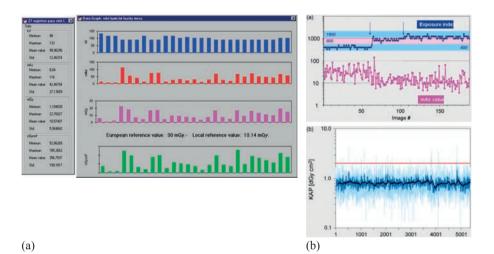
(a) An on-line patient dose monitoring system developed for computed radiography auditing [13]. (b) Top: anteroposterior lumbar spine radiograph exposure. Small alterations of the automated exposure control are indicated (arrows). Bottom: automated assessment of the kerma area product in posteroanterior chest radiographs. The majority of exposures are below the diagnostic reference level (red line) [3].
